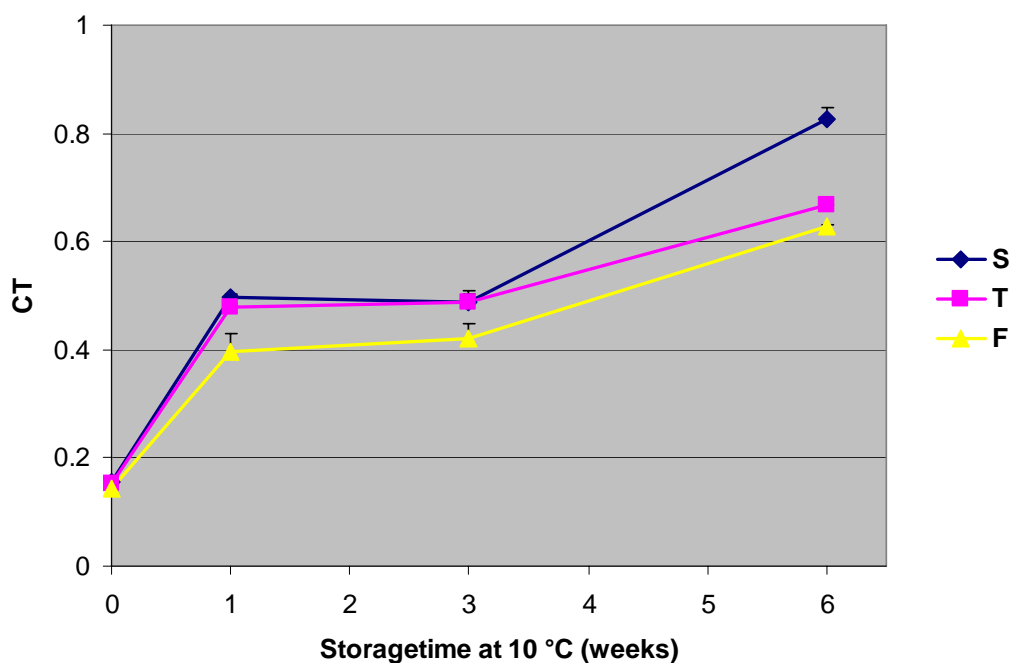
Changes in conjugated trienes (CT) during storage of mayonnaise ($n = 2$). For abbreviations, see Figure 1.
